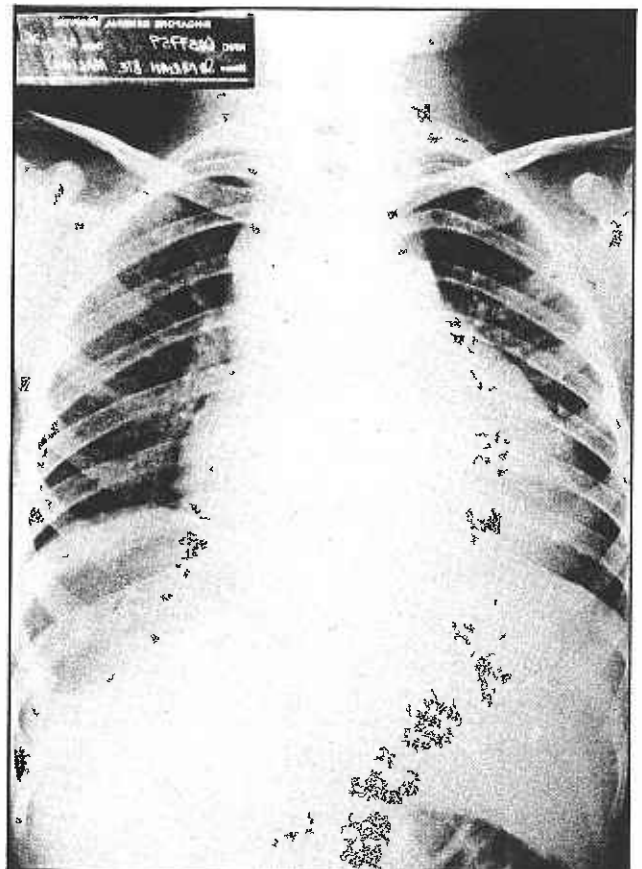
Chest roentgenogram showing heart in the usual left hemithorax but the liver shadow also situated in the left upper abdomen (laevocardia with situs inversus).
